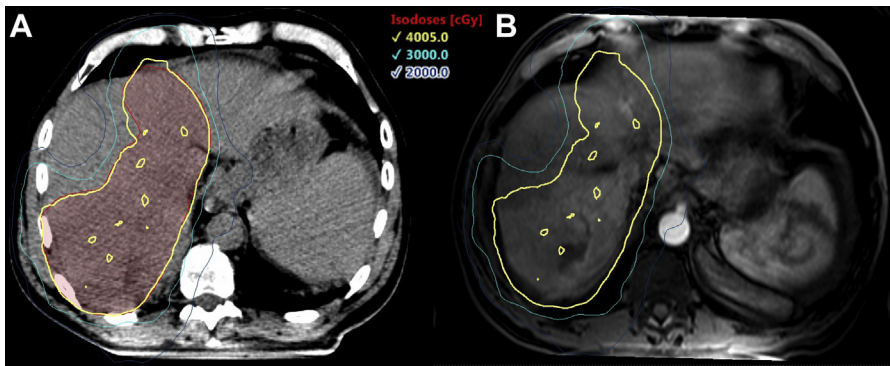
IMRT for unresectable HCC. A 64-year-old man with a history of hepatitis C–related cirrhosis developed an HCC with portal vein involvement and an AFP of 19,497 ng/mL. He was Child-Pugh A and was treated with IMRT (4005 cGy in 15 fractions) and sorafenib in 2014. (A) IMRT plan on planning CT. Isodose lines represented in absolute dose (cGy). (B) IMRT plan projected on pretreatment MRI abdomen. His AFP nadired to 6 and remained low with no recurrent disease until about 2 years post-treatment. His AFP increased to 19 and he underwent another course of IMRT in late 2016. He had control for another few years but ultimately progressed and went on nivolumab. He completed a third course of EBRT in 2019. Although, his HCC has since progressed locally, he remains alive as of August 2020.
